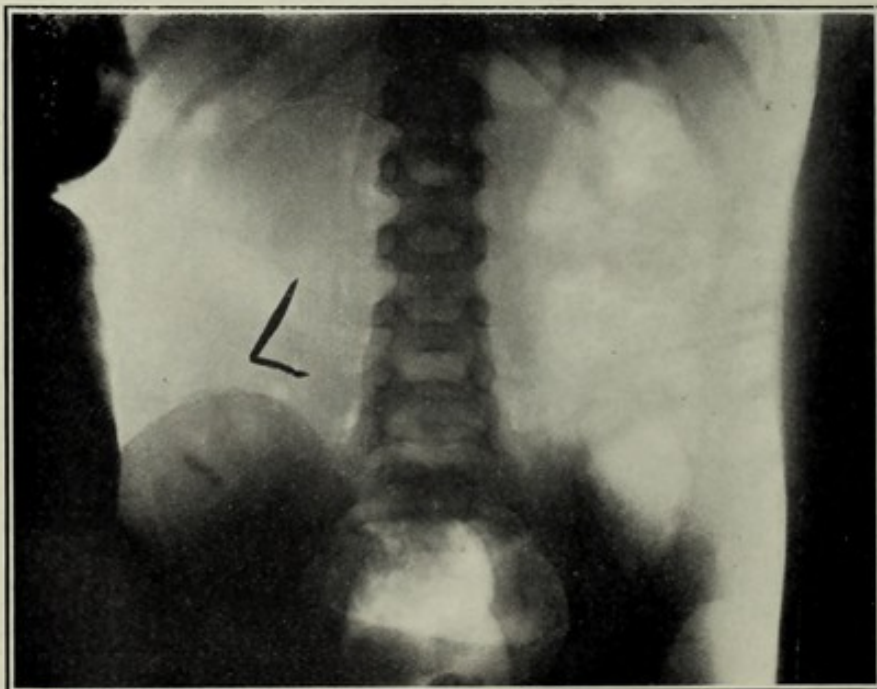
X-ray appearances in a case of suspected calculus before the patient has been properly prepared for the exposure.
